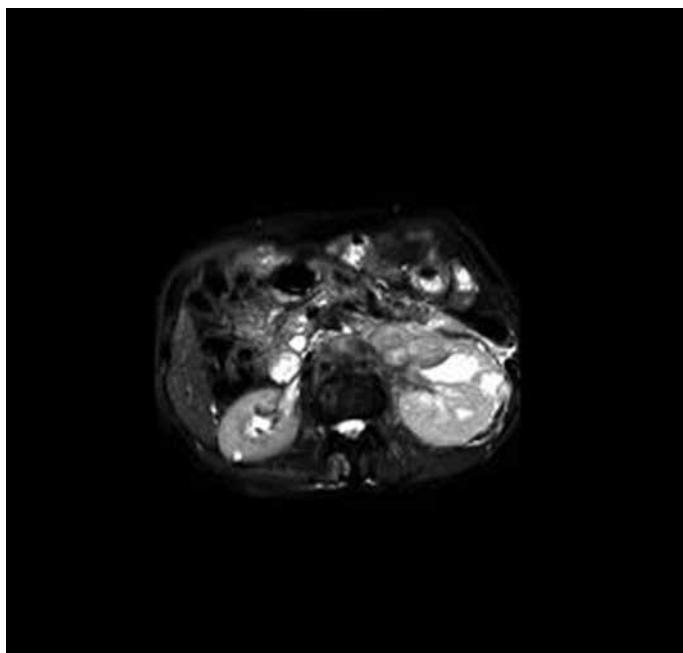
Axial magnetic resonance images with contrast infusion
